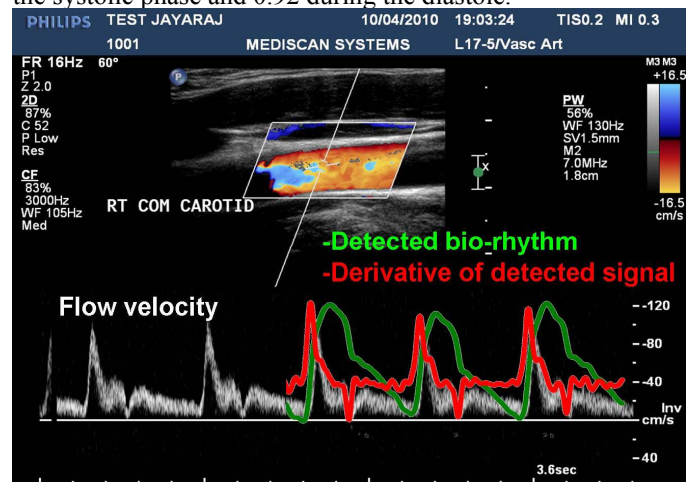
Doppler image of the carotid artery showing the blood flow velocity waveform overlaid with the detected bio-rhythm and its derivative
